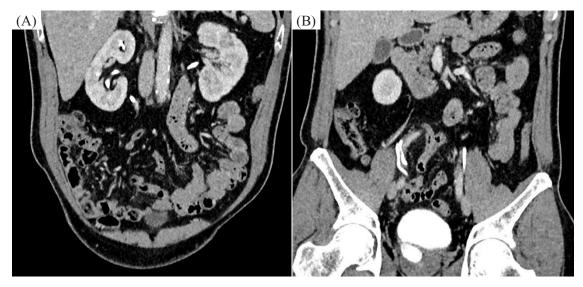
(A) Contrast CT imaging showing duplex kidney with contrast in upper and lower moieties draining via a single ureter and (B) inverted Y ureteral duplication with contrast drained into bladder and prostatic ureter via ectopic ureterocele.
